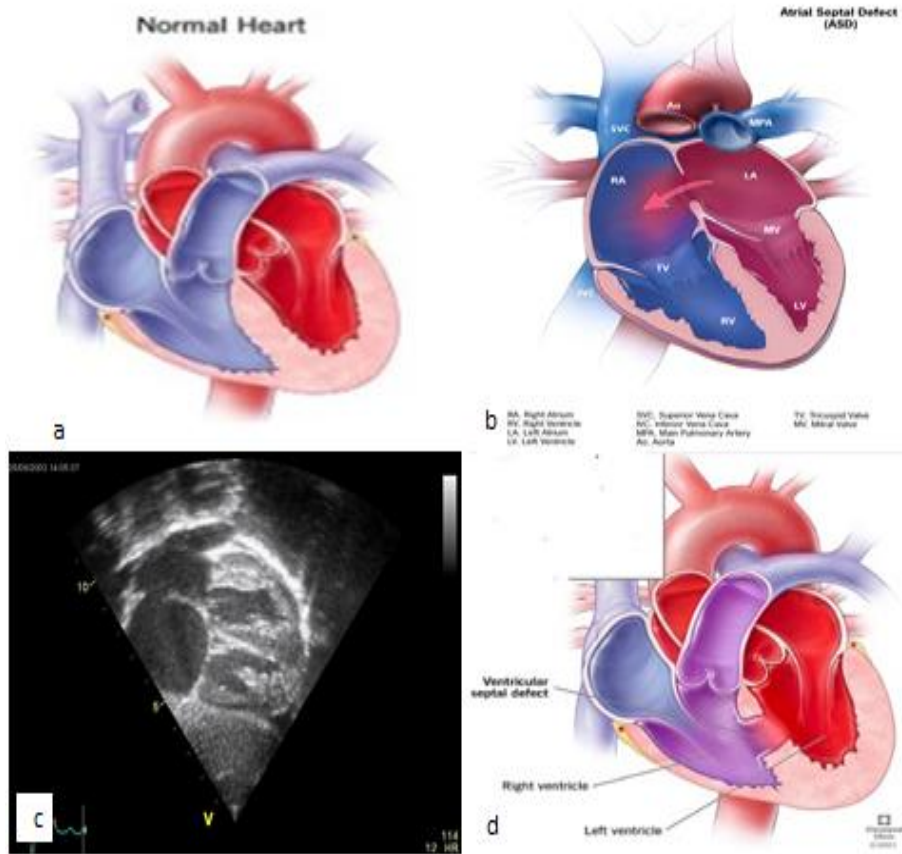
a. Picture of normal heart; b. Atrial septal defect.(<http://www.statpearls.com>); c. Atrial septal defect by an ultrasound; d. Ventricular septal defect (<https://my.clevelandclinic.org/health/diseases/17615-ventricular-septal-defects-vsd>)
